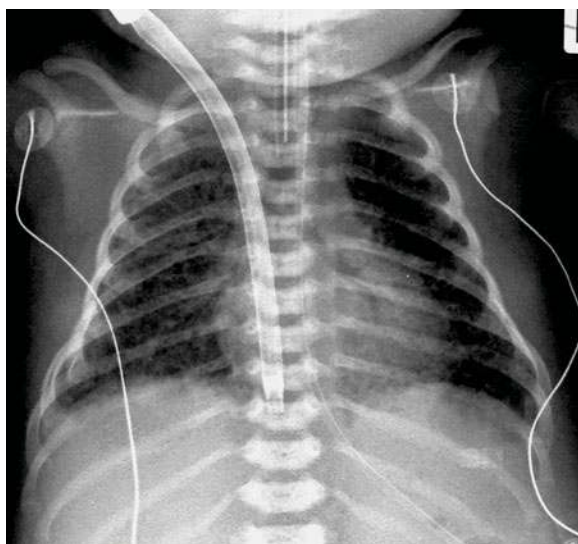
Chest X-ray of a child with MAS treated with VV ECMO. The large VV ECMO catheter is noted with its tip in the right atrium. MAS has caused asymmetrical coarse reticulonodular change in the lungs
